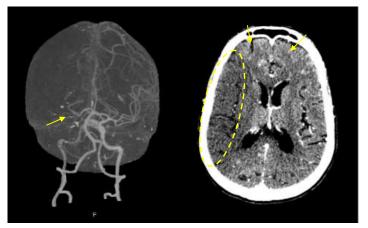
(Left) Computed tomography angiography of the head demonstrating a decrease in attenuation and caliber distal to the bifurcation (arrow) at the level of the internal carotid artery terminus with faint intermittent contrast distally that quickly dissipates. There is poor leptomeningeal collateral flow in the right hemisphere. (Right) Acute right middle cerebral artery infarction (circle) with slight effacement of the sulci and right to left shift with faint peripheral petechial hemorrhage (arrow).
